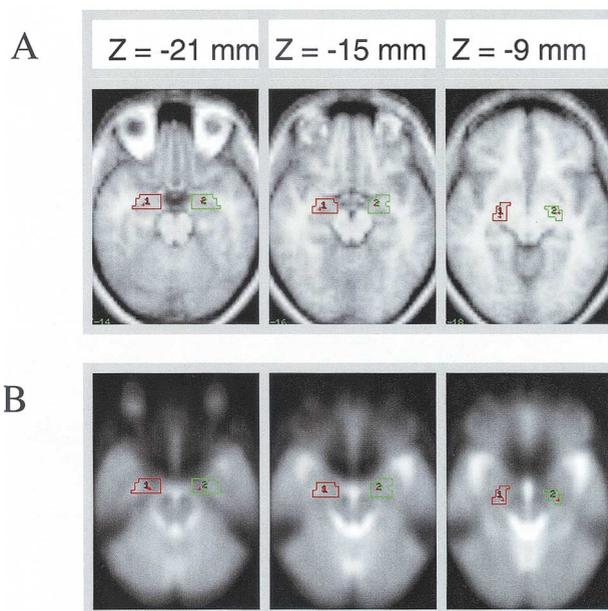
(A) Magnetic resonance image scans were combined and averaged for all the subjects. A priori left and right amygdala regions of interest were drawn on this combined image, as shown above in axial sections, for use in analysis of variance comparisons of the effect of emotional faces on amygdala activation in depressed and control subjects. (B) Functional data, and the first blood oxygenation level-dependent (BOLD) run were combined from all subjects, and the regions of interest (ROIs), left and right amygdala, were superimposed. The area of susceptibility artifact can be seen anterior to, but not including, the amygdala ROIs.
